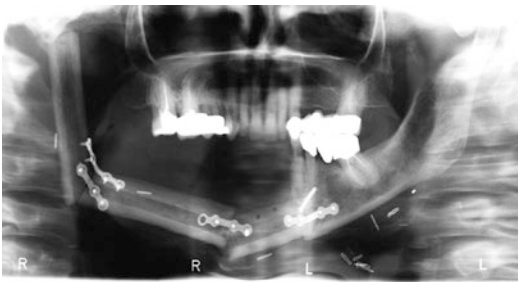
Postoperative radiographic control a three months of the case presented in Figs. 5 and 6
